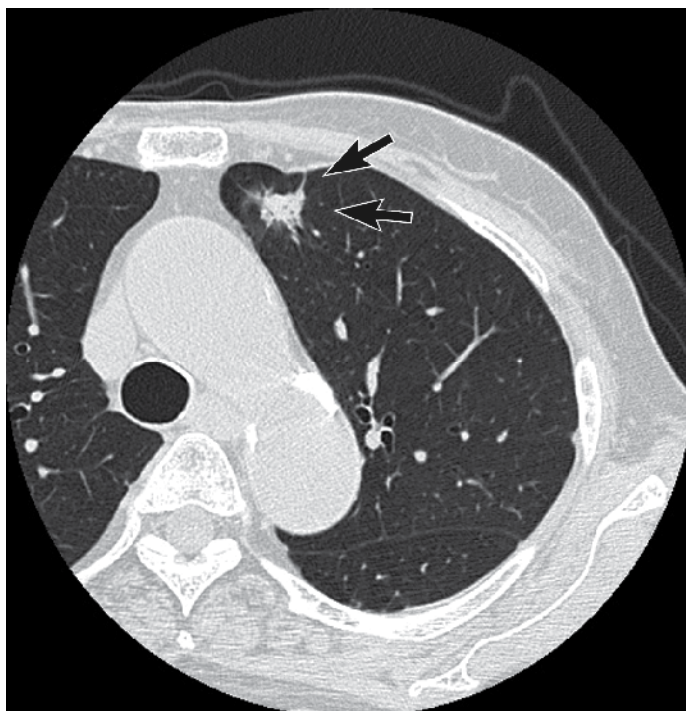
Computed tomography demonstrates a small spiculated lung mass periphery in the left upper lobe of the lung.
